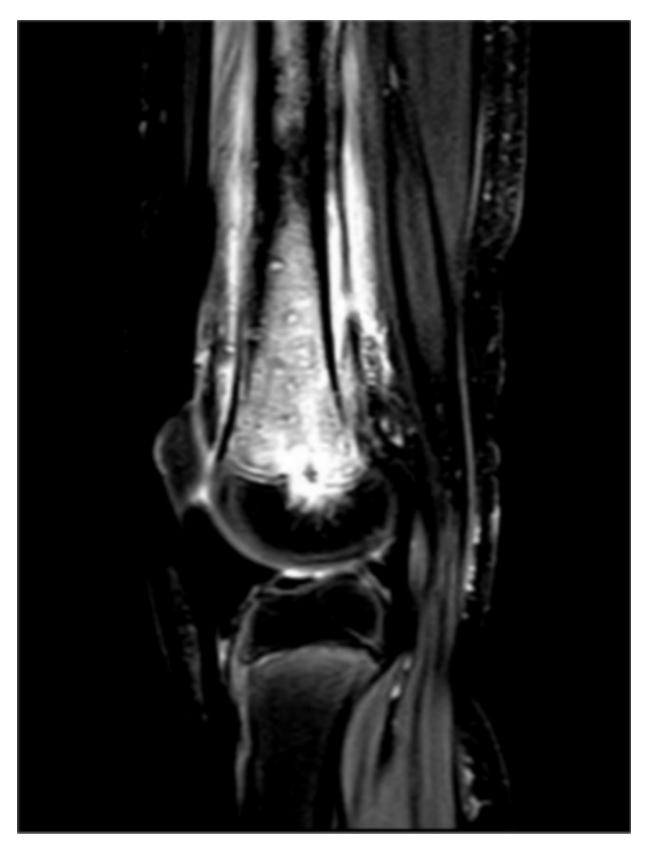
An 8-year-old girl presented with a 10-day history of distal femur pain and fever. MRI revealed distal left femoral osteomyelitis with periosteal elevation and rupture. Intraoperative knee aspiration yielded clear, pale-red fluid without pus, suggesting a reactive effusion. Beneath the periosteum of the distal left femur, a large amount of thick, yellowish-white pus was discovered, with an infectious perforation allowing the pus to flow into the subcutaneous tissue. The final diagnosis was left femur osteomyelitis with a periosteal abscess
